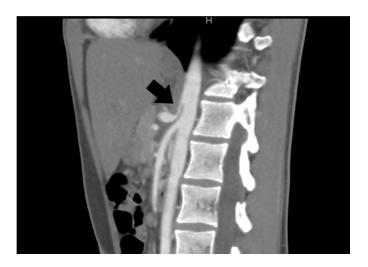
Computed tomography angiography abdomen and pelvis demonstrating narrowing of the celiac artery in a J-shaped configuration with post stenotic dilation seen in median arcuate ligament syndrome (arrow).
